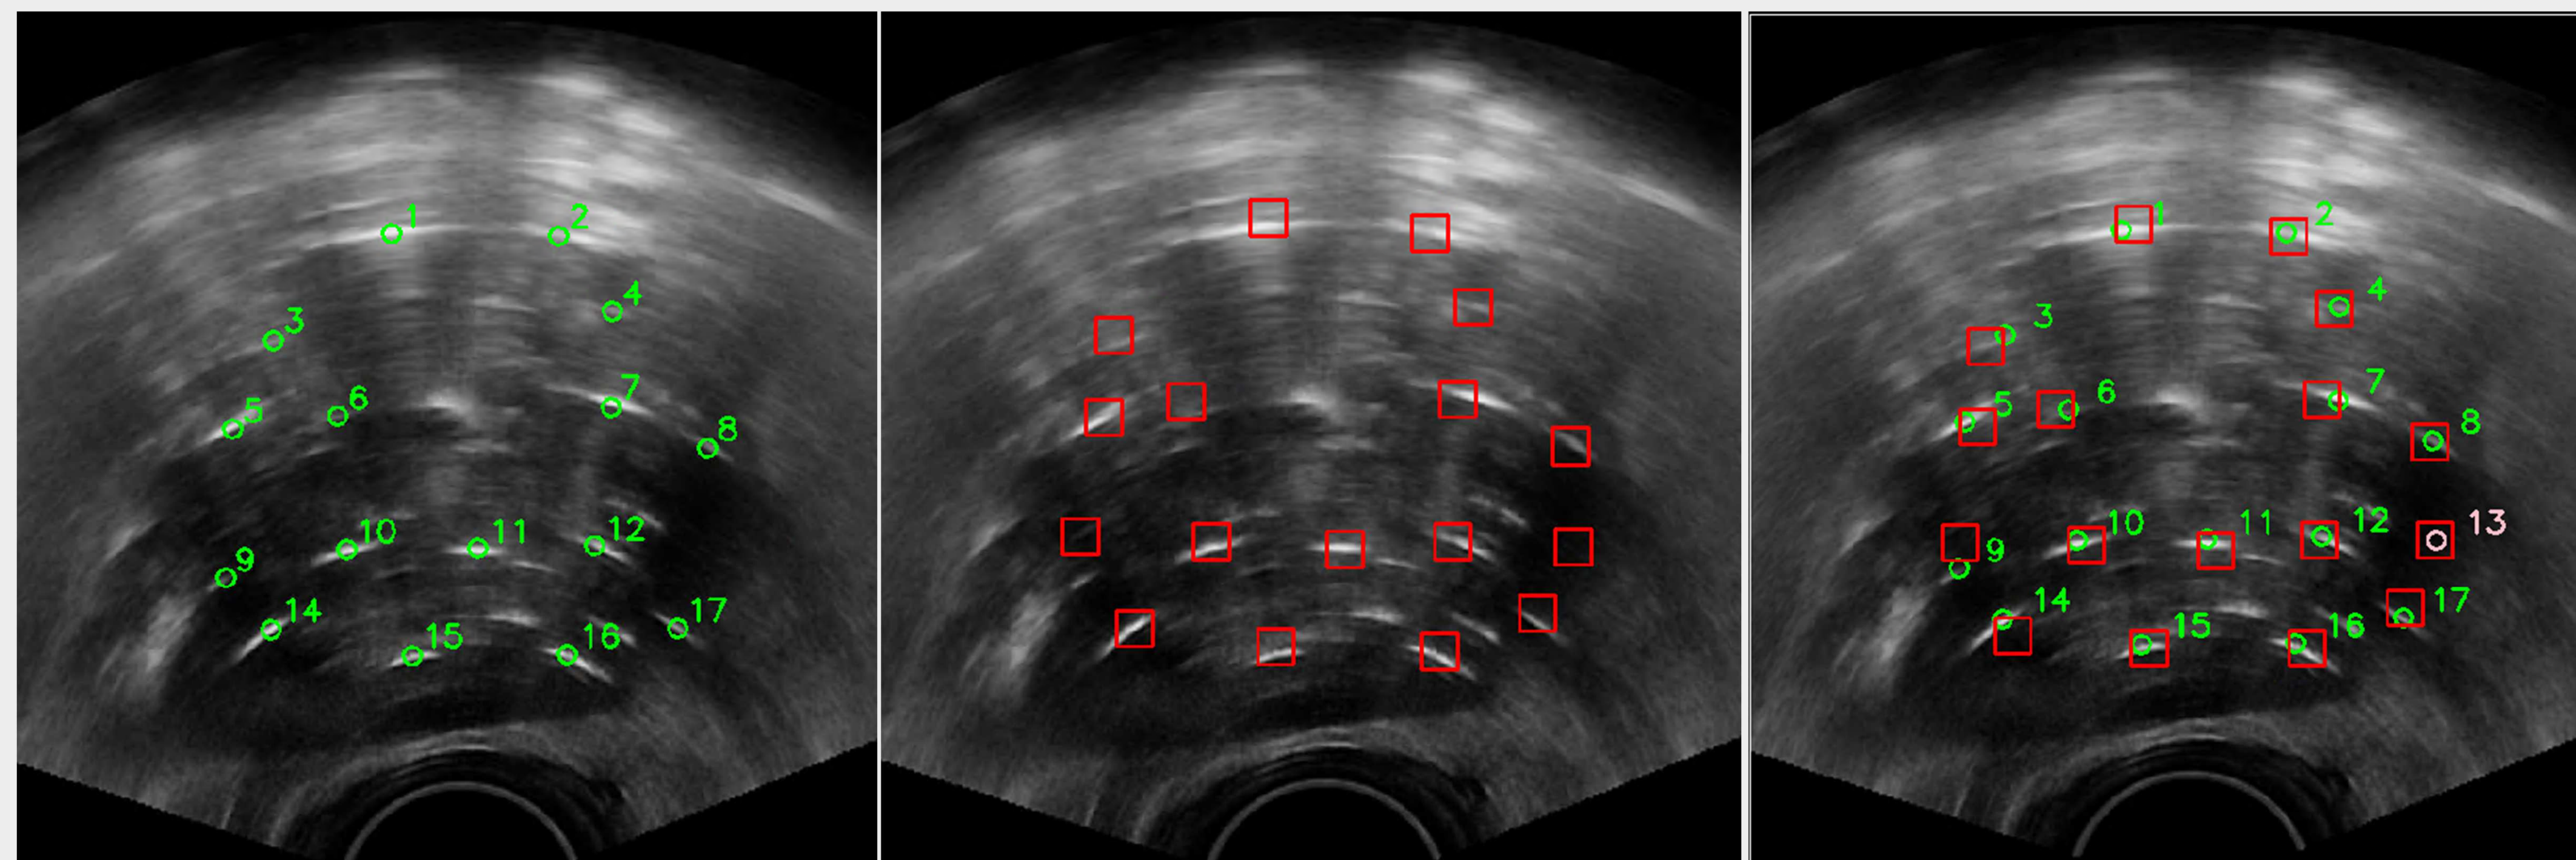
Left: CorneliUS automated catheter reconstruction (numbered green circles) on a post-implant 3D ultrasound image. Center: Needle instances detected by CorneliOLO during implantation (red squares) on a 2D axial ultrasound. Right: Affine registration aligning post-implant and live-implant needles. The final location of needle 13 (missing from the 3D reconstruction) is inferred from its live-implant coordinates.
